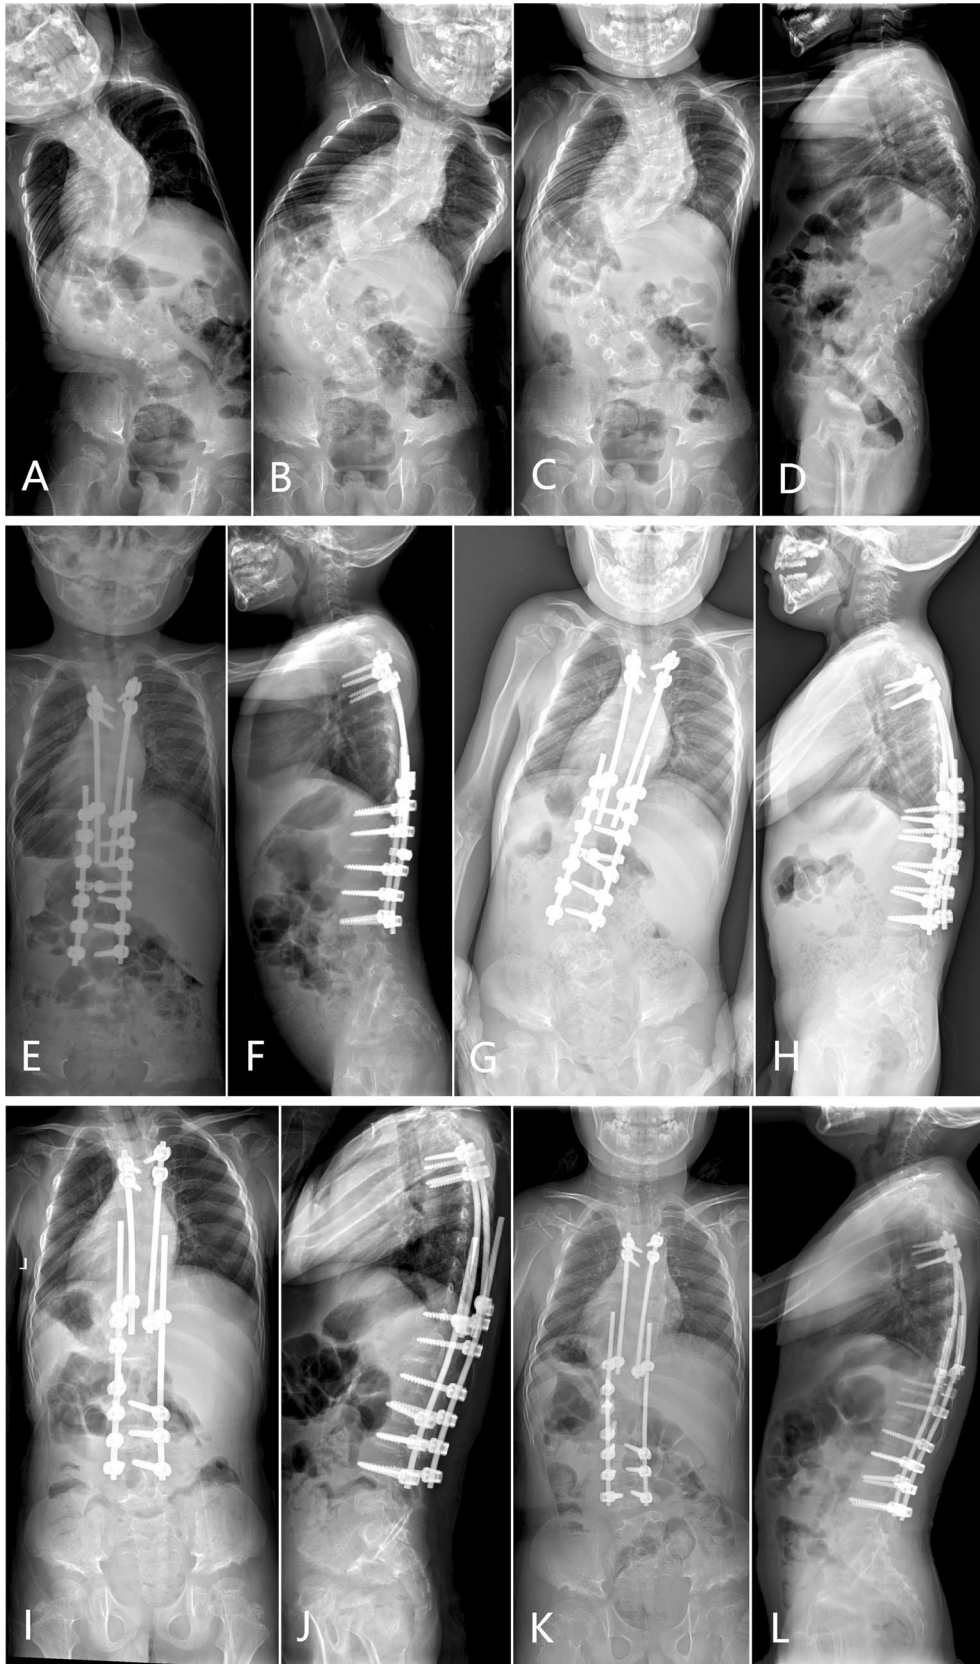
X-rays of Patient 1. (A–D): Preoperative X-rays at the age of 4, including side-bending X-rays (A, B) and whole spine X-rays (C, D). (E, F) Immediate postoperative x-rays after the initial surgery. (G, H) X-rays at 18 months after the initial surgery indicating a coronal imbalance. (I, J) Immediate postoperative X-rays after the revision surgery, during which the level of the lowest instrumented vertebra was extended from L3 to L4. (K, L) X-rays at the latest follow-up after the 7th growing rod extension.
